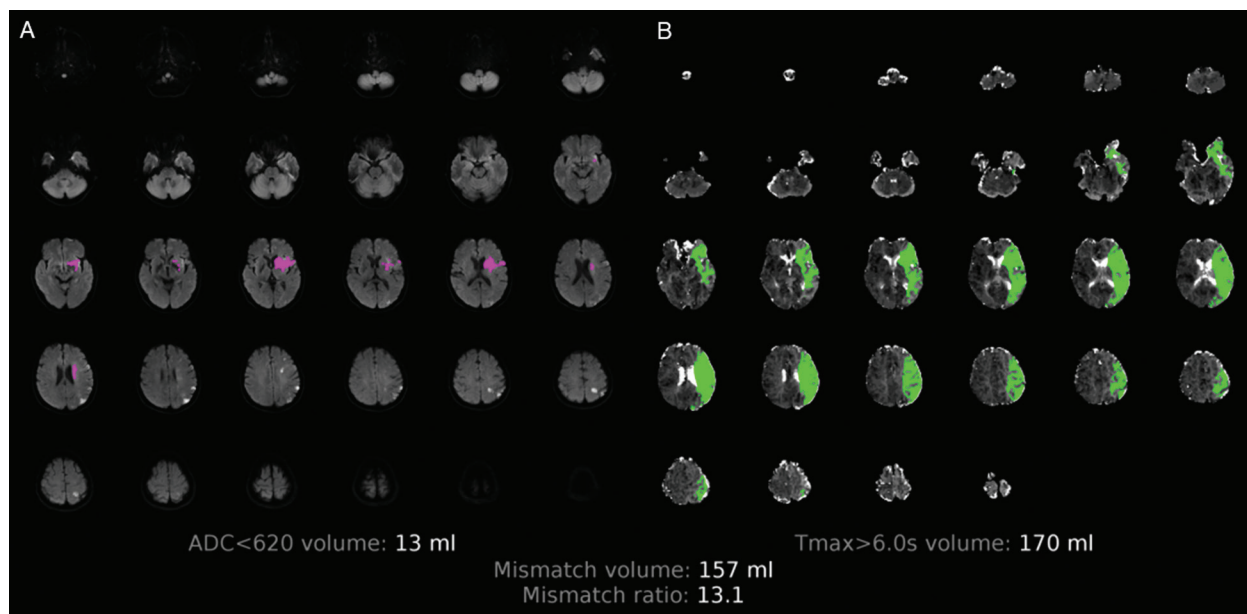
The automated image postprocessing system (RAPID) on admission. (A) DWIs overlaid with the stroke core identified using the apparent diffusion coefficient threshold. The estimated stroke core was 13 mL. (B) T_{max} maps with green overlay for regions with abnormal flow ($T_{max} > 6$ sec). The estimated volume of delayed flow was 170 mL. The diffusion–perfusion mismatch ratio was 13.1. DWI: diffusion-weighted image
